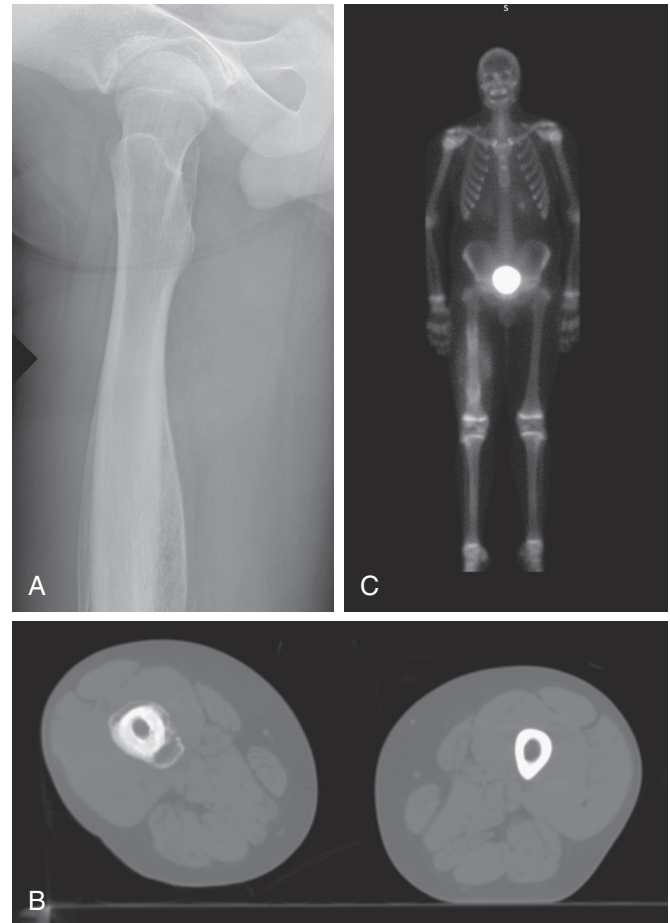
A, Plain radiograph; B, axial CT; and C, 99mTc bone scan of Ewing's sarcoma of right femur.
